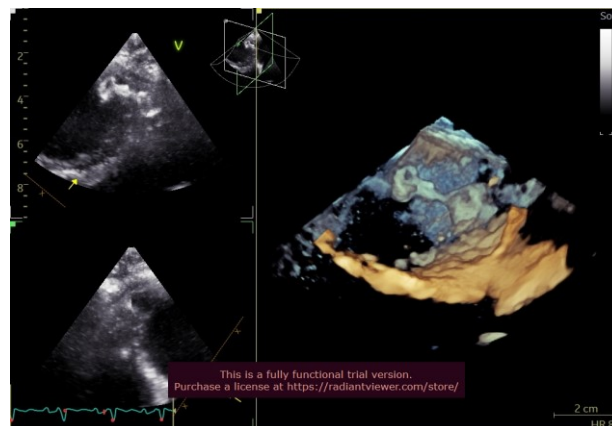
3D transthoracic echocardiography after percutaneous transcatheter closure of VSR with lifetech MFO 8/10 mm
